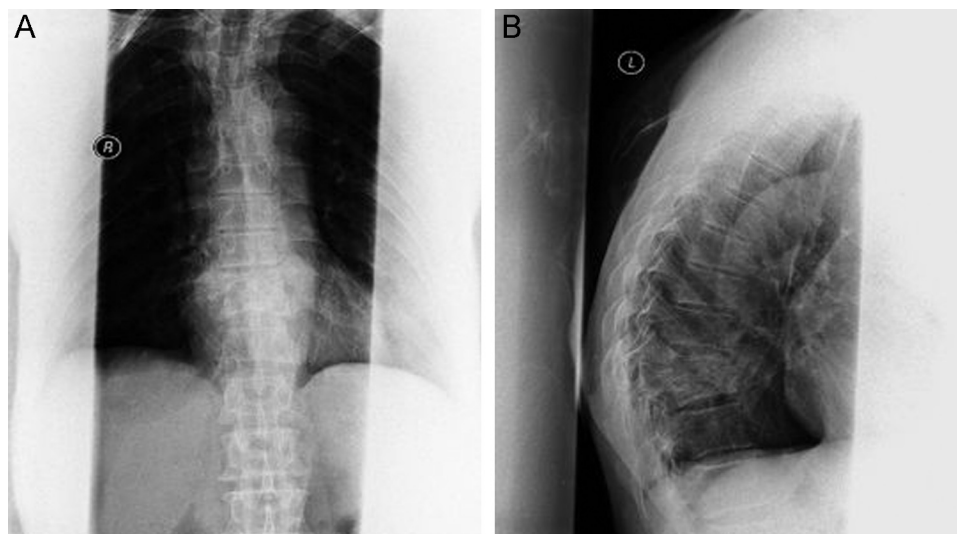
The X-ray of the spine after second surgery.
